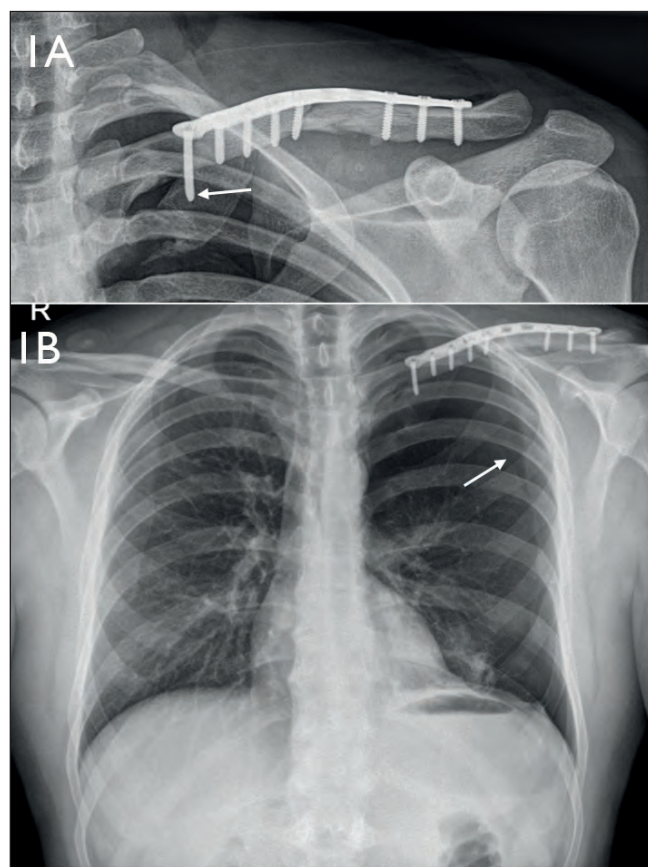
(top): left clavicle check x-ray demonstrating an apical pneumothorax and an excessively long medial screw (white arrow); Figure 1b (bottom) demonstrating a left-sided pneumothorax (white arrow pointing to edge of lung).
